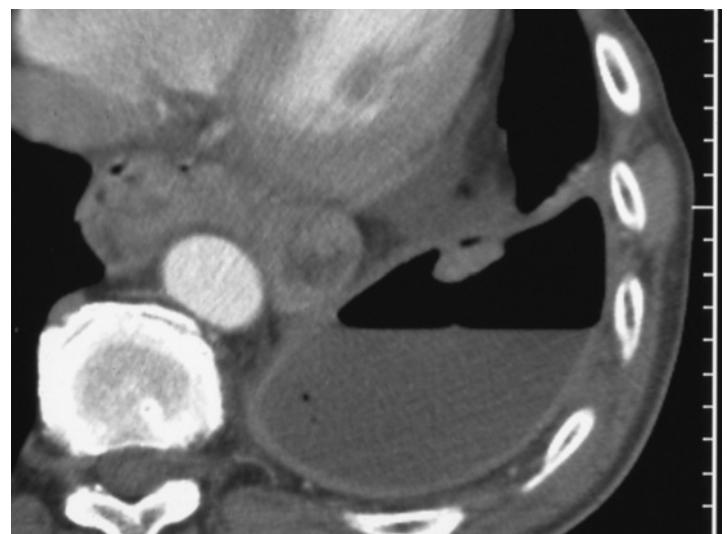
CT image of the thickened visceral and parietal pleura. Pleural empyema already treated by aspiration and drainage; the thickened layers of the pleura can be differentiated because of the air inclusion.
